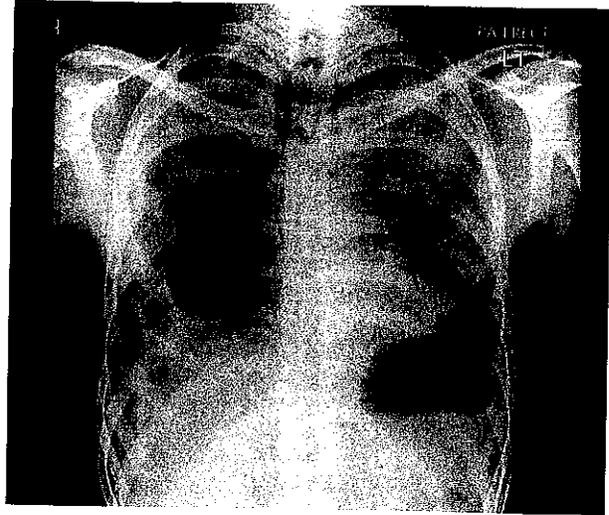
Chest X-ray in a patient with silicosis.
